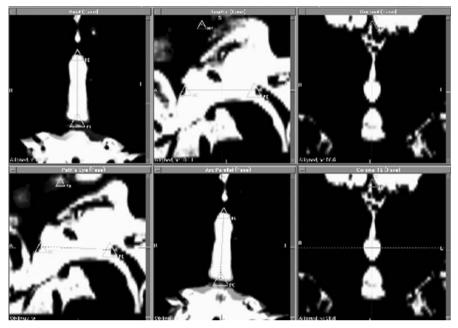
Determination of intercommissural line by surgiplan. FASE image (heavy T2) is used to determine AC and PC and consequently the IC line is drawn. Upper three MR images were used. *Left*: Axial plane, *center*: Sagittal plane, *right*: Coronal plane. All images change together with the same 3D coordinate
